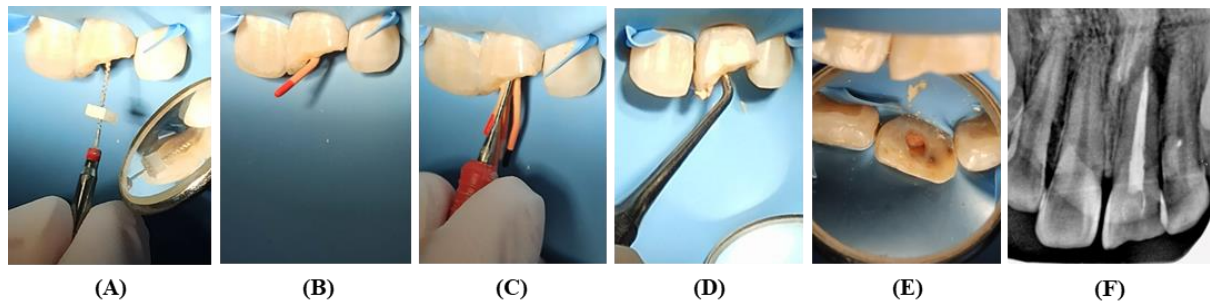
Sealar application (A), MAC (B), Obturation with lateral condensation and gutta percha assecory (C), Vertical cutting of gutta percha and condensation (D, E), Radiograph after root canal obturation (F)
